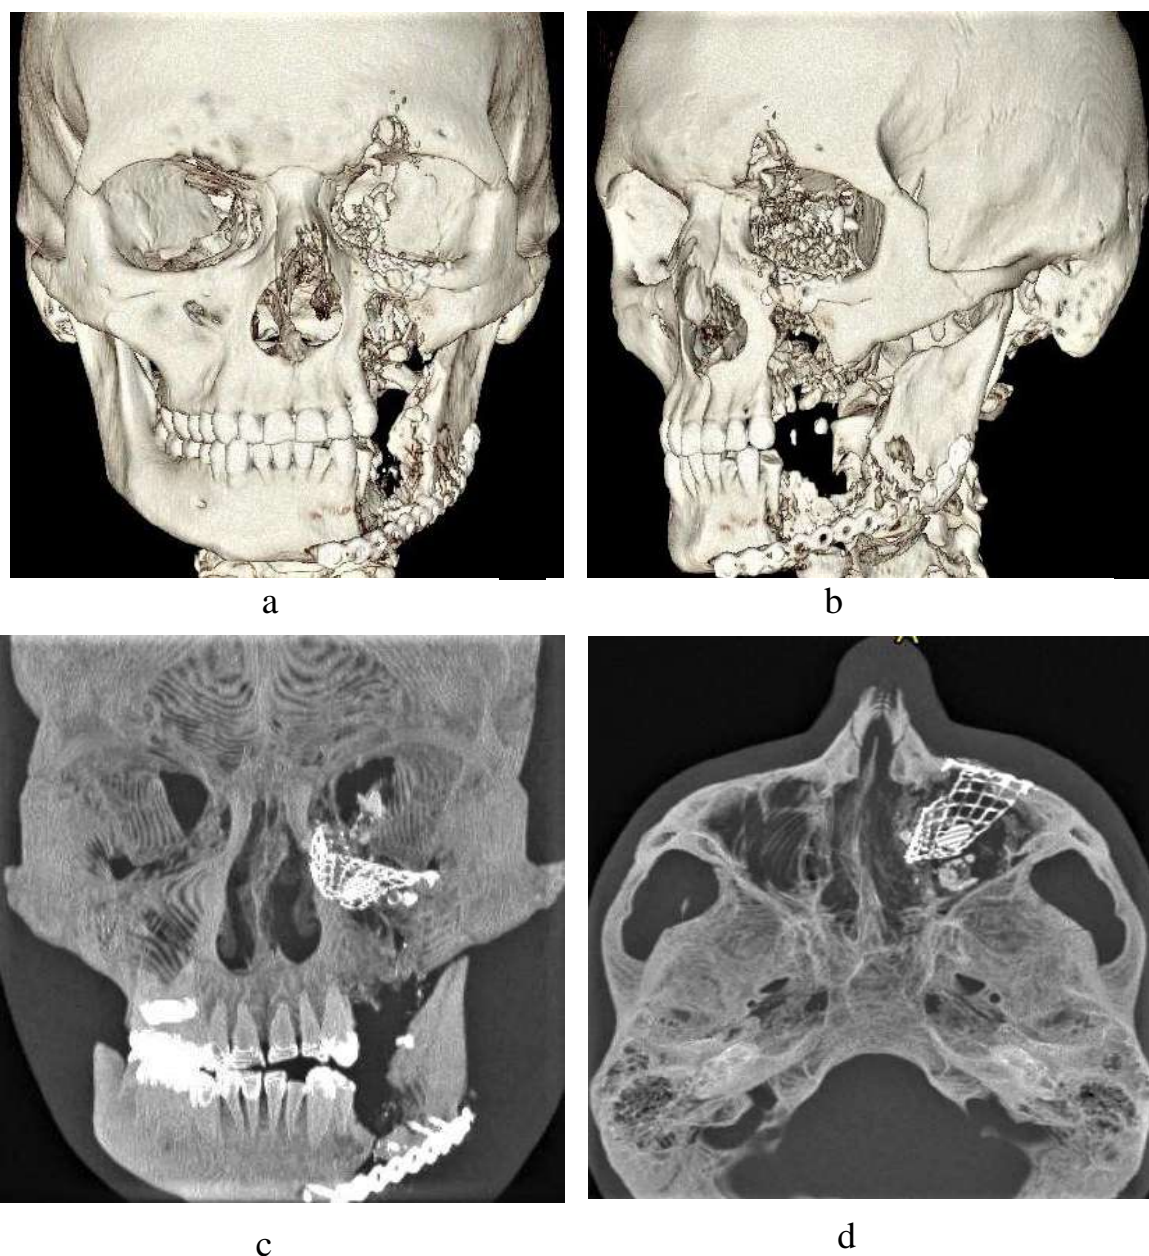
CT scan of the skull of the injured individual C., 19 years old, after the reconstructive-restorative stage of surgical treatment: a) straight view; b) left lateral view; c) axial projection; d) coronal projection.
